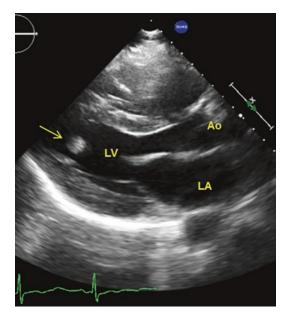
Parasternal long axis from a patient with a small left ventricular myxoma (arrow), located near the ventricular apex
